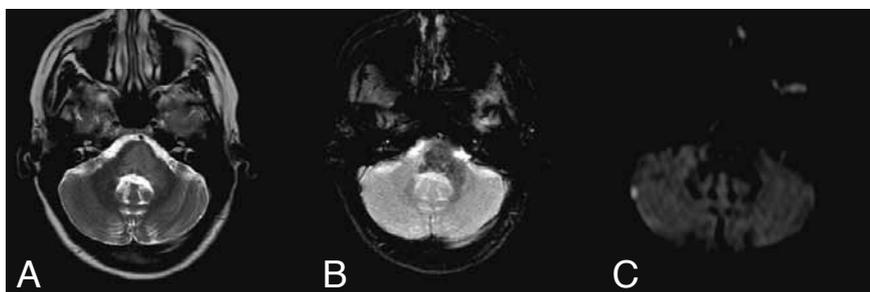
A. Axial T2-weighted image: a large hyperintense area is seen in the pons. B. Gradient echo-sequence: low signal intensity is present in the lesion. C. DWI (b = 1000): no diffusion restriction is seen.
